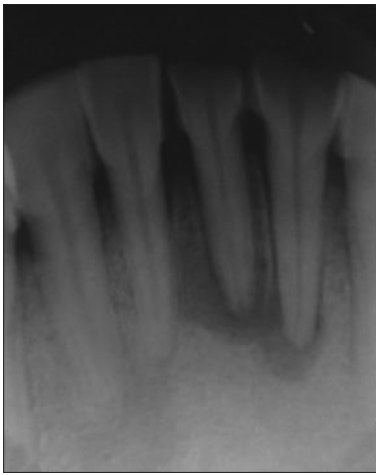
Intraoral periapical radiograph showing periapical lesions
